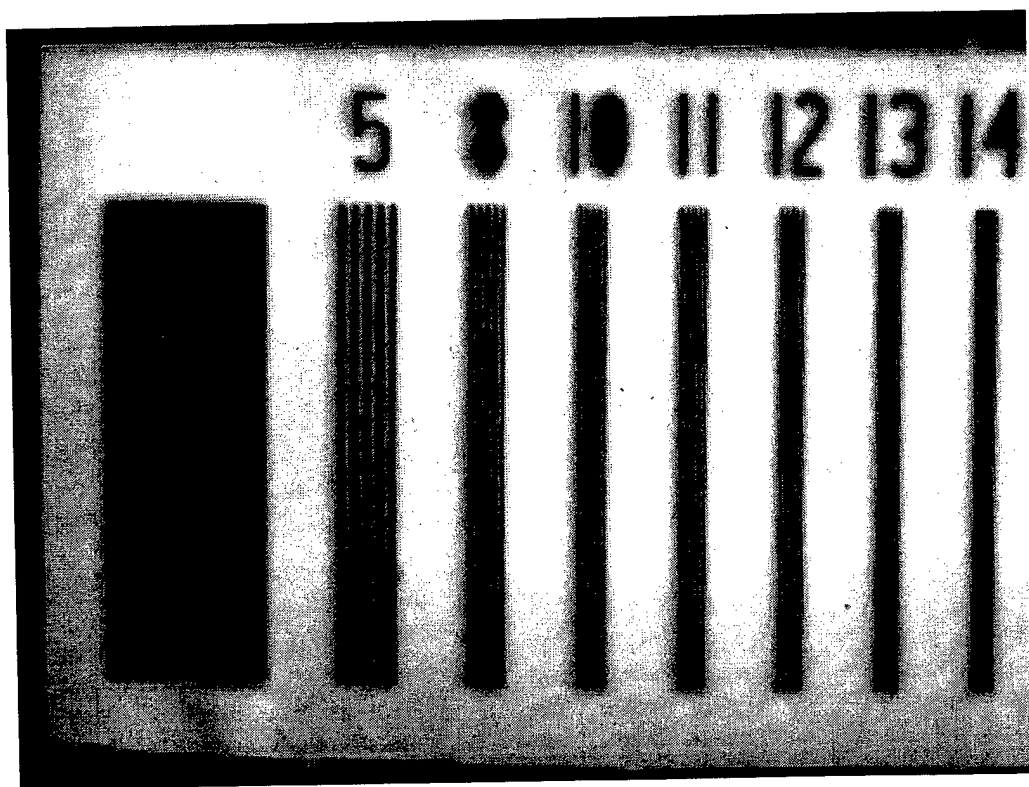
This image shows the resolution obtained with a standard X-ray resolution bar pattern. The numbers at the top represent resolution in line-pairs per mm. The resolution approaches the limit of the detector at 12 lp/mm (0.0415 mm line width) since the pixel size at the image plane is 0.043 mm.
